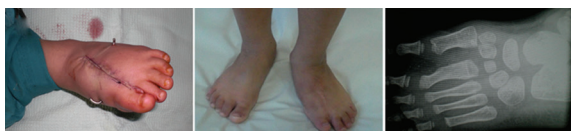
Case 2, Surgical figures and final shape. a) Central ray resection; b, c) Foot shape and radiograph (with extra cuneiform) 3 years after surgery
